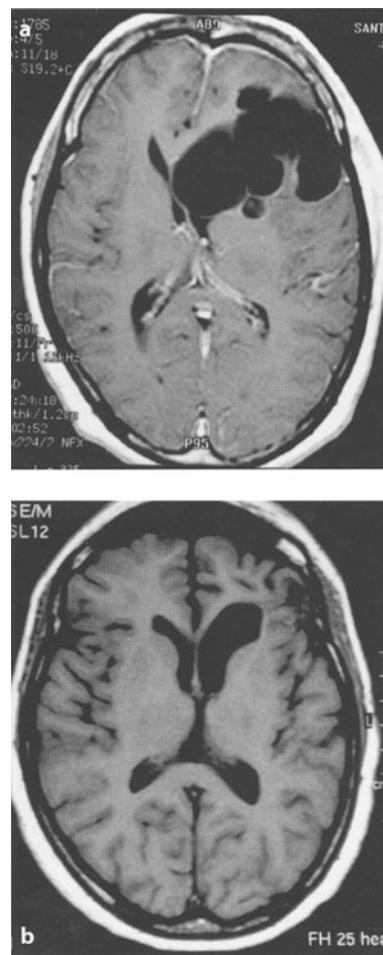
Axial enhanced T1-weighted MRI. Clusters of cysticerci arising from the sylvian fissure. Note the normal ventricular size. b Axial unenhanced T1-weighted MRI, postoperative follow-up after endoscopy
